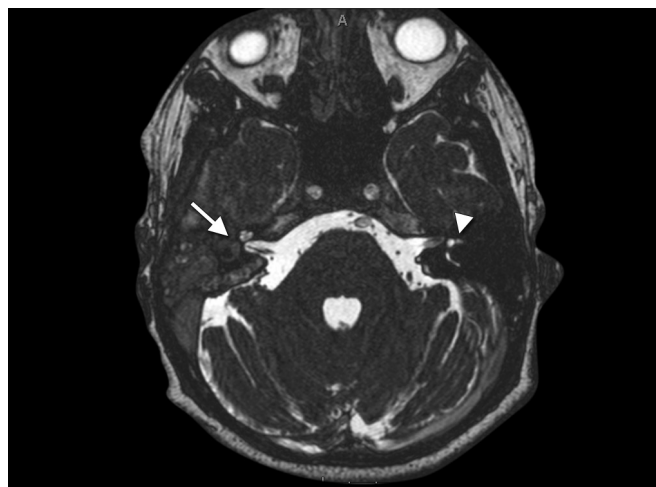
Labyrinthitis MRI CISS. Constructive interference in steady state (CISS) gradient echo sequence of the same patient provides good resolution and reveals a lack of signal in the right vestibule and semicircular canals (white arrow) in contrast to the normal high signal expected as in the unaffected contralateral side (white arrowhead).
